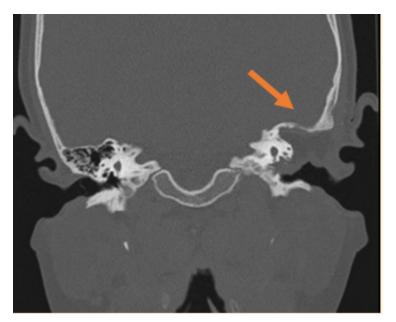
Post-surgical high resolution computerized tomography (HRCT) temporal bone done after 3 months showed the repaired site of tegmen tympani.
